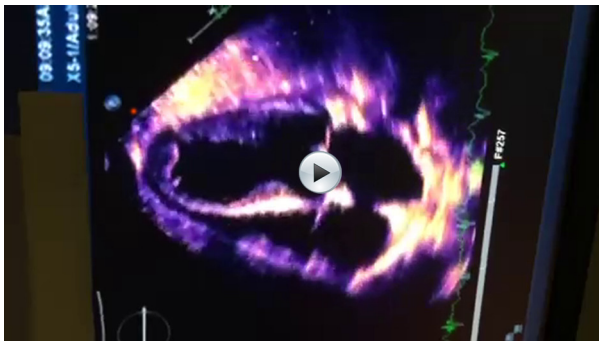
Transthoracic echocardiogram showing a calcified apical thrombus and global hypokinesis.
